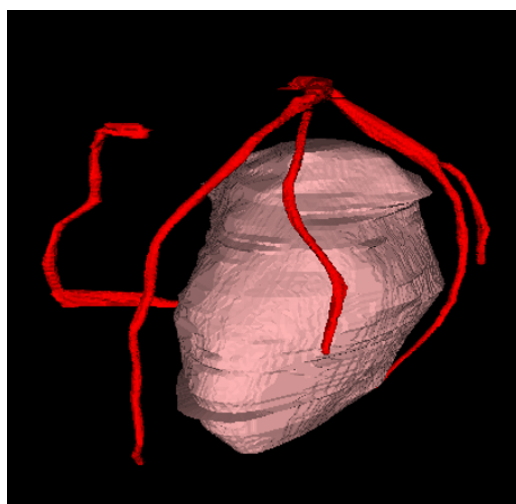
Computed tomography contours of the endocardial left ventricle (pink) and coronary arteries (red).
